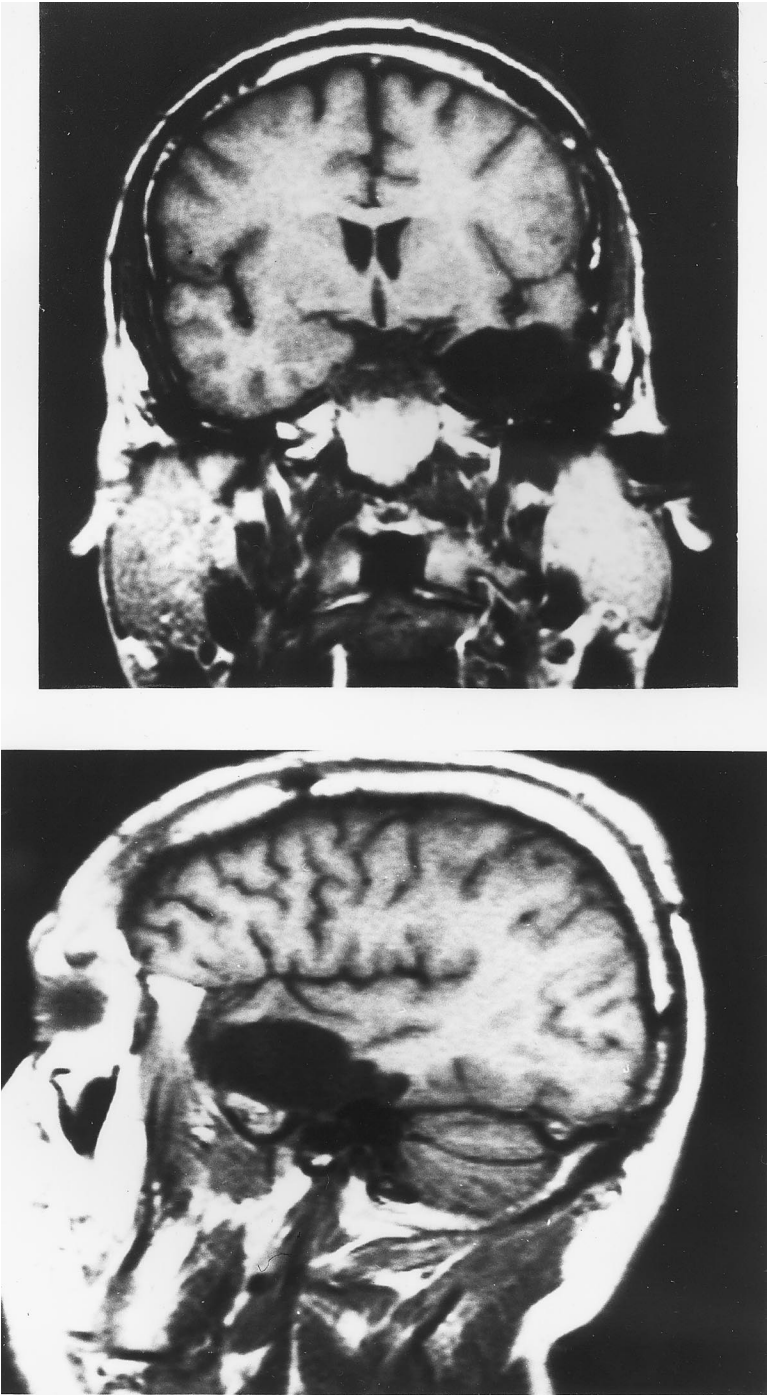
Representative postoperative T1-weighted MRI scans demonstrating the extent of the surgical procedure: Coronal and parasagittal sections.
